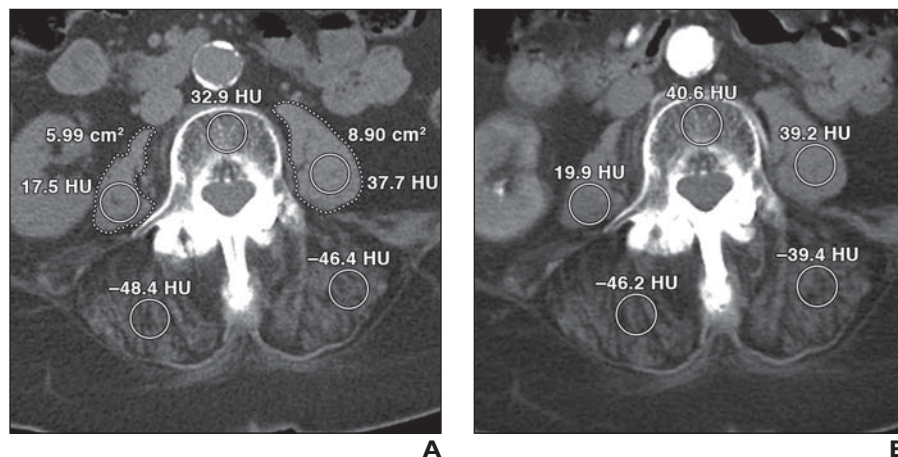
88-year-old woman with right upper quadrant and back pain. (Reprinted from [20]) A–D, Representative four-phase CT scans obtained in unenhanced phase (A), arterial phase (B), portal phase (C), and delayed phase (D) show ROIs (*circles*) for psoas muscles, posterior paraspinal muscles, and L4 vertebral body. For example, attenuation of L4 vertebral body increased from 32.9 HU in unenhanced phase to 40.6 HU in arterial phase, 50.3 HU in portal phase, and 59.5 HU in delayed phase. Attenuation of abdominal aorta also was measured on each of four phases of CT examination at L3 level above level of aortic bifurcation (not shown). In A, dotted lines show freehand ROIs drawn on unenhanced images outlining both psoas muscles.
